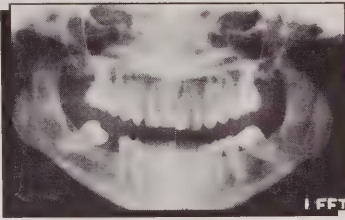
Pretreatment panoramic radiograph (molar uprighting).
